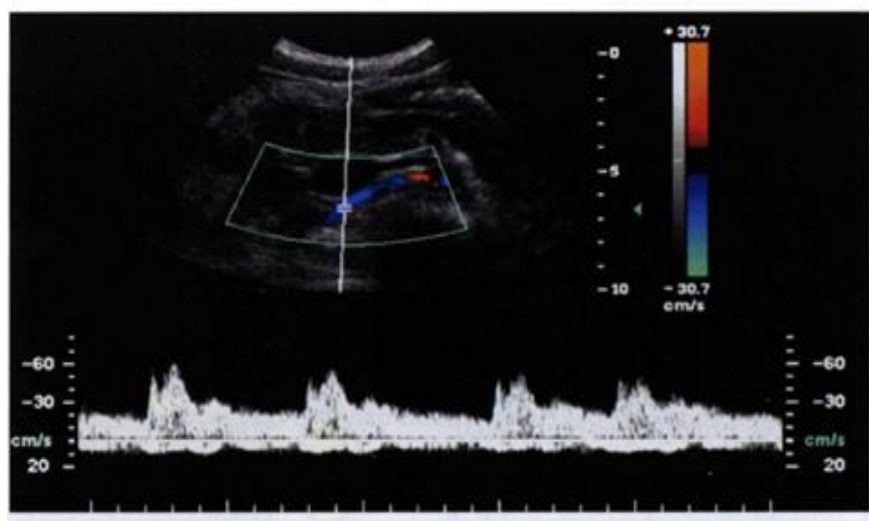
The above image shows the Doppler tracing from a right renal artery demonstrating the usual early systolic spike that is seen in normal patients.
